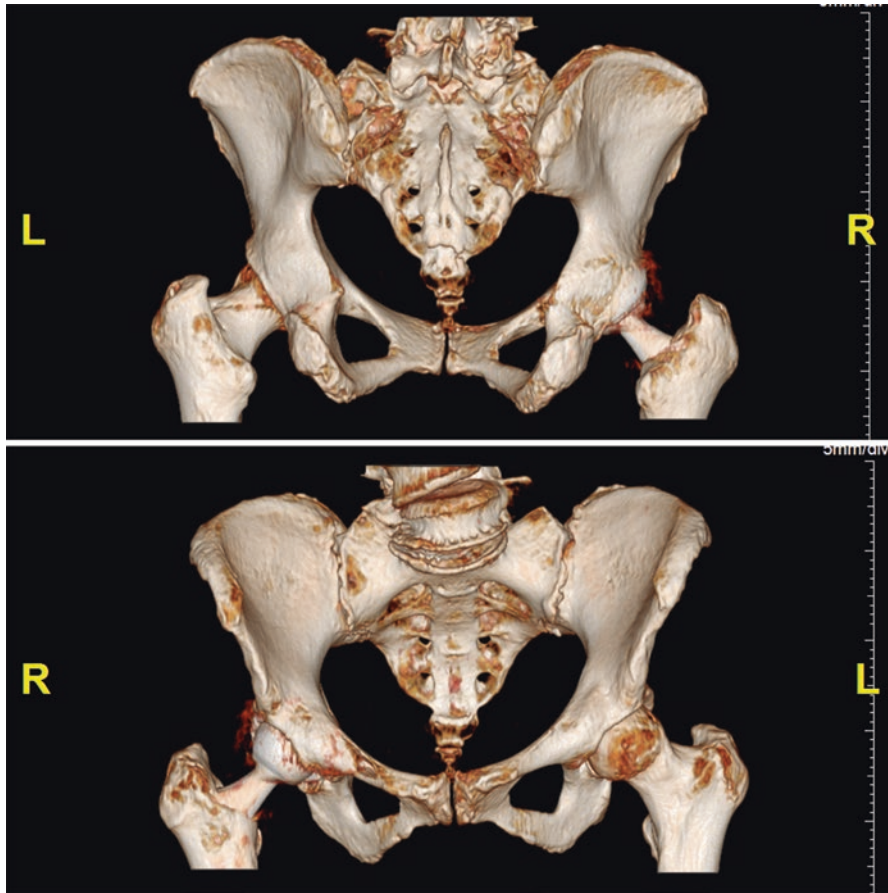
3D CT images from 81-year-old female patient
